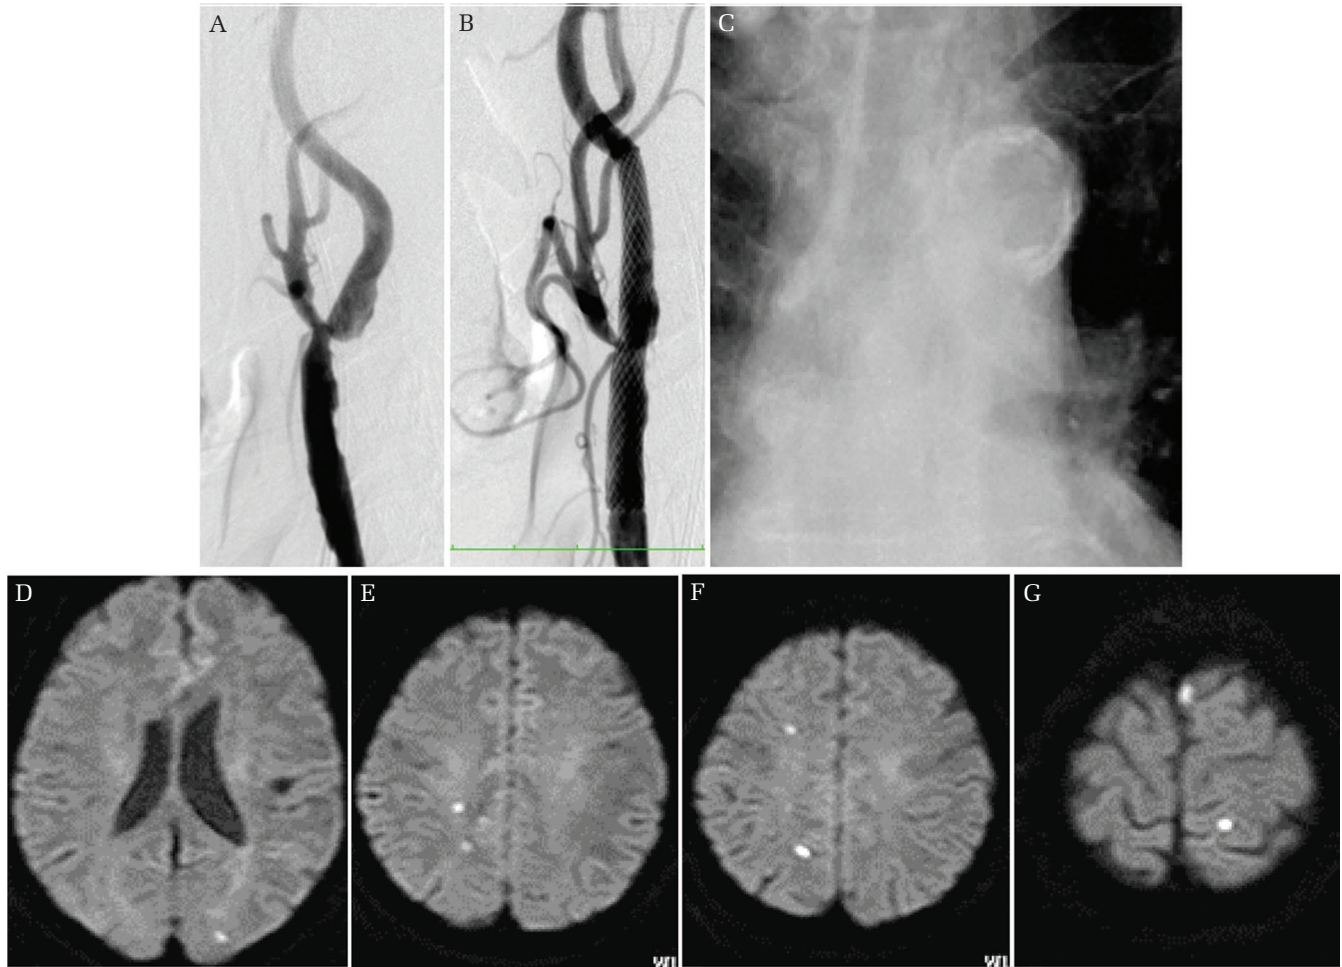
Left-sided CAS was performed in an 81-year-old man who presented with a minor stroke. (A) Angiogram of the left carotid artery before stenting, showing a 65% stenosis of the internal carotid artery. (B) Angiogram after stenting shows successful dilatation of the carotid lumen. (C) AAC on chest X-ray indicated Shimada's grade 3. (D–G) Postprocedural diffusion-weighted magnetic resonance imaging showed multiple MIs in both cerebral hemispheres.
